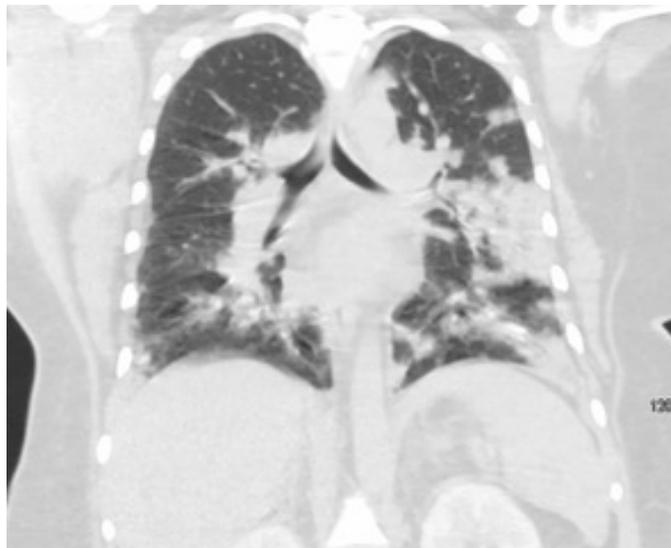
CT Sagittal view showing bilateral pulmonary infiltrates on hospital Day 1
